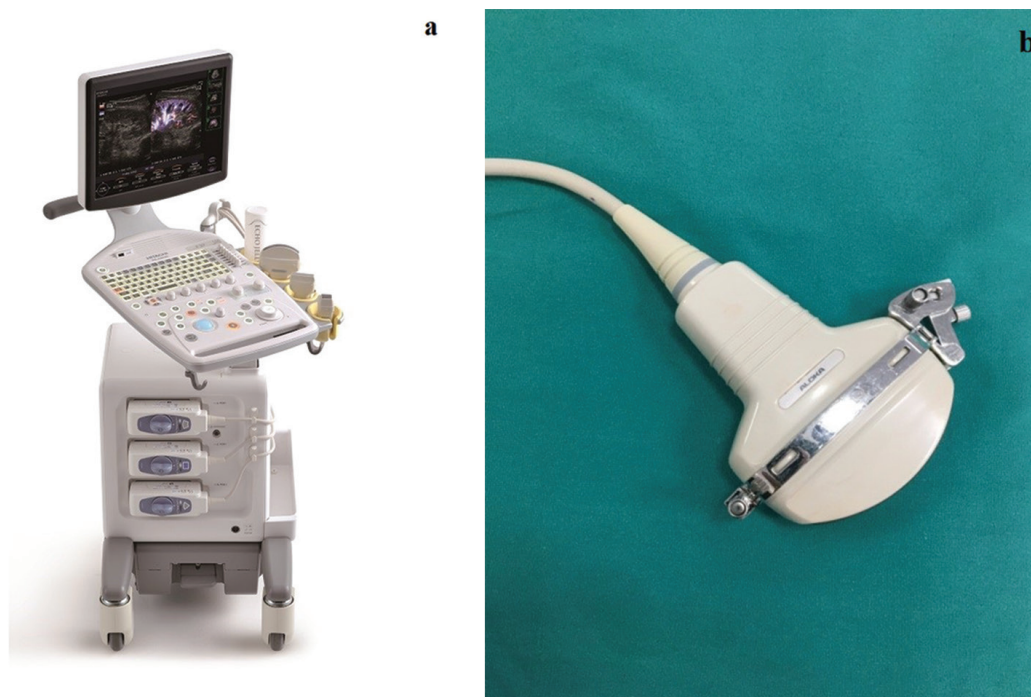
a) Ultrasound device HITACHI ALOKA f37; b) convex transducer with biopsy attachment.
